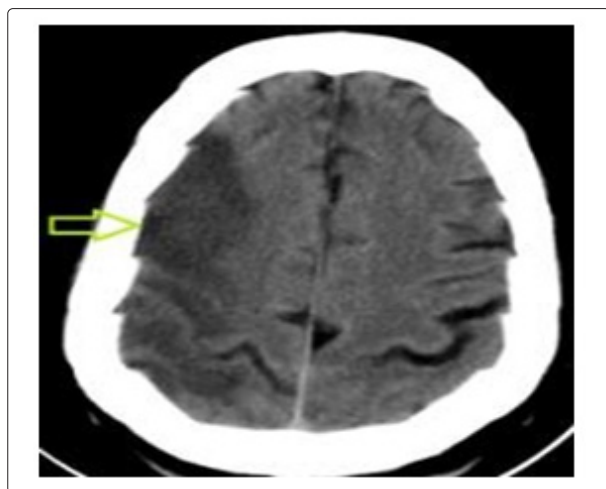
CT brain coronal section showing right MCA (Middle Cerebral Artery) territory infarct (arrow).
